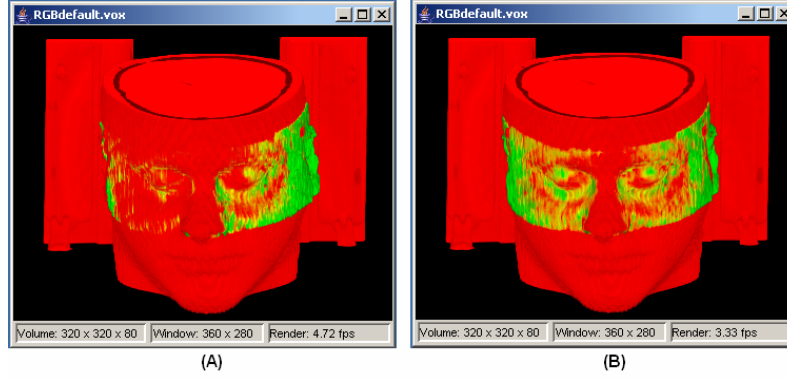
Global positioning error found in the 3P registration (A) and corrected by the 3D registration (B). CT (red) and MR (green) are used.
